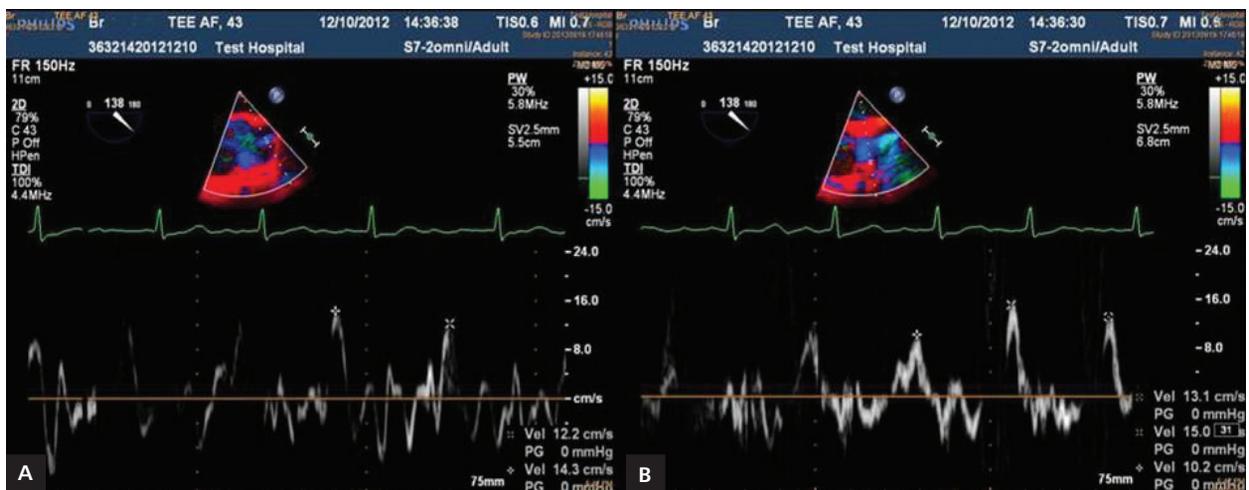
Assessment of movement velocity of lateral (A) and medial (B) right atrial appendage wall by means of transoesophageal echocardiography spectral tissue Doppler imaging
